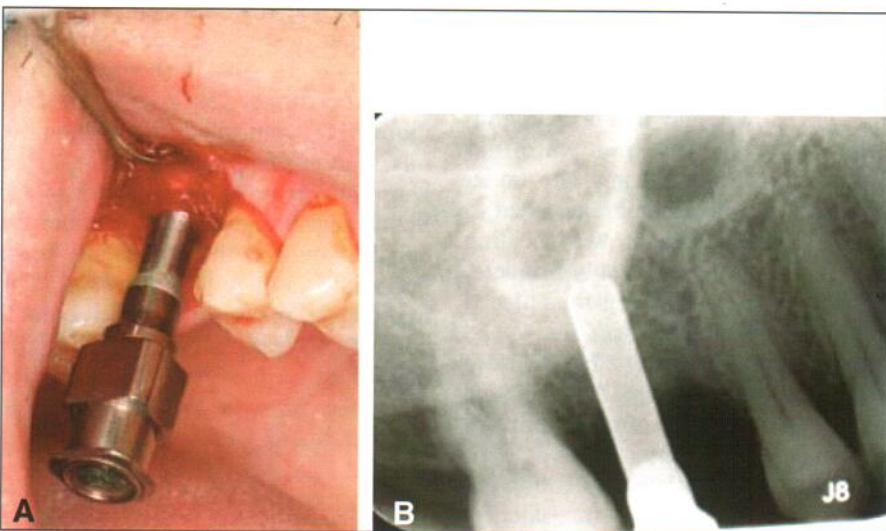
Luer-Loc cannula with tapered plug-in end inserted. A, Intraoral view. B, Radiographic image.
